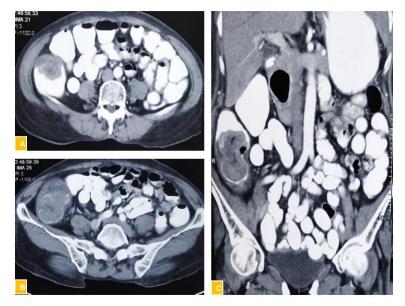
(A-C): Contrast enhancing CT abdomen showing mass involving caecum and ascending colon
